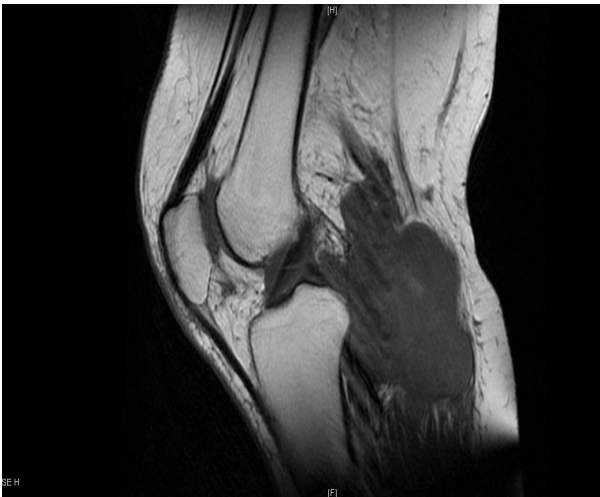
MRI (Coronal Section) of the knee showing clearly the popliteal mass
